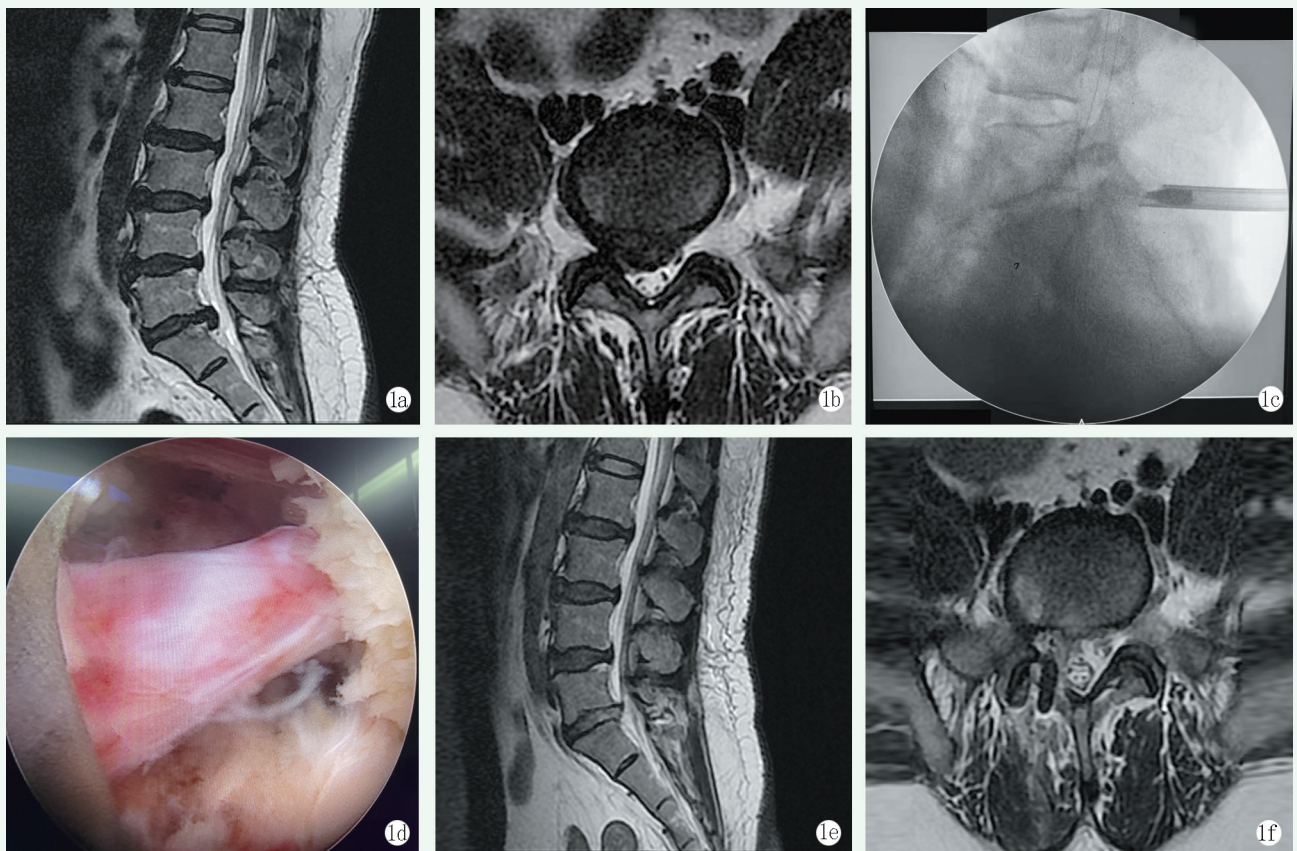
患者，男，53 岁，右臀部疼痛伴右下肢麻木 10 余天，诊断 L₅S₁ 椎管狭窄症，行后入路内镜下髓核摘除术。1a: 术前 MRI 示 L₅S₁ 椎间盘脱出，继发椎管狭窄，椎间隙高度 7 mm，腰椎前凸角 25.9°；1b: 术前 MRI 示 L₅S₁ 椎间盘中央偏右突出，椎管面积 113 mm²；1c: 术中于 L₅S₁ 椎板间隙置入内镜工作通道；1d: 术中髓核摘除后 S₁ 神经根彻底减压松解；1e: 术后 MRI 示 L₅S₁ 脱出椎间盘已摘除，椎间隙高度 7 mm，腰椎前凸角 26.3°；1f: 术后 MRI 示 L₅S₁ 突出椎间盘已摘除，椎管面积 305 mm²。
